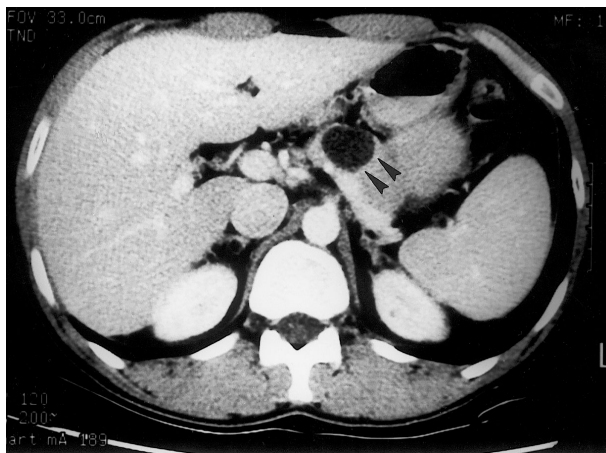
Abdominal CT with contrast showing a well-defined hypodense, cystic lesion in the mid-portion of the pancreas.
